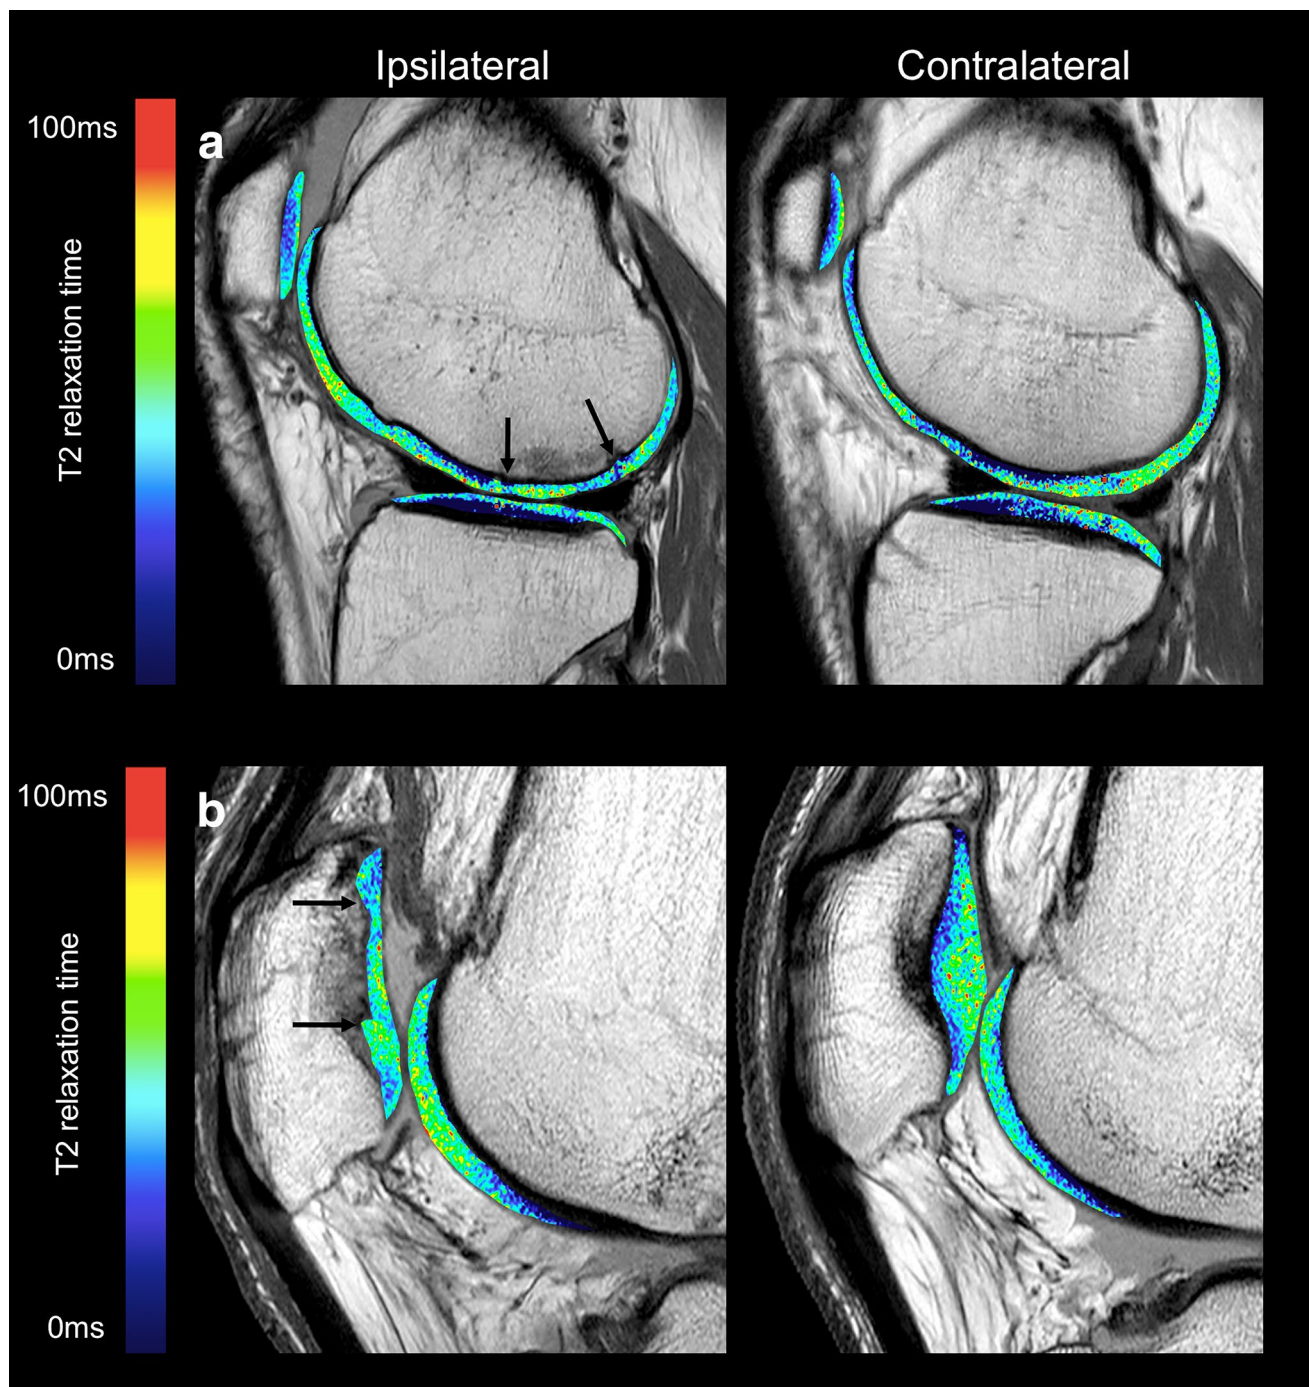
Cartilage T2 relaxation time maps overlaying the first echo of the T2-weighted multi-slice-multi-echo spin-echo sequences from the ipsilateral and the contralateral knee of two patients who received osteochondral repair. a Patient with osteochondral repair at the lateral femoral condyle. b Patient with osteochondral repair at the patella. Arrows mark the borders of the osteochondral repair tissue. Blue colour represents low T2-values, indicating intact cartilage matrix
